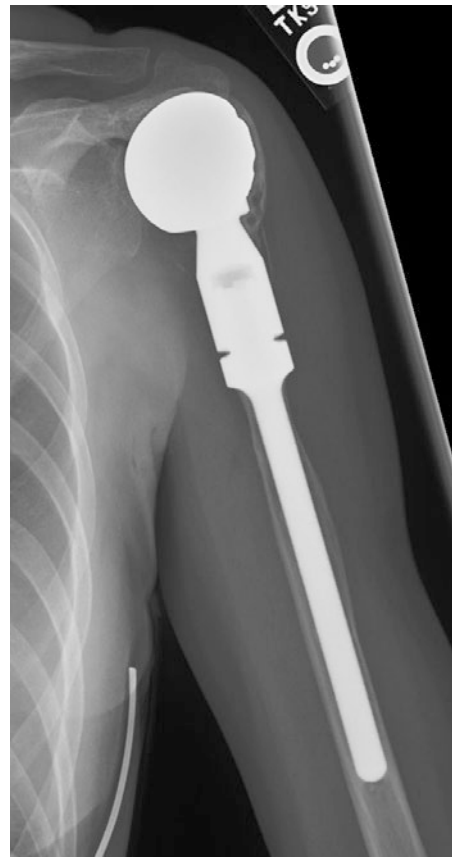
Oncologic shoulder arthroplasty. AP radiograph of the left shoulder shows a long-stemmed humeral component with resection of a large amount of humeral bone stock in a patient with benign bone neoplasm
